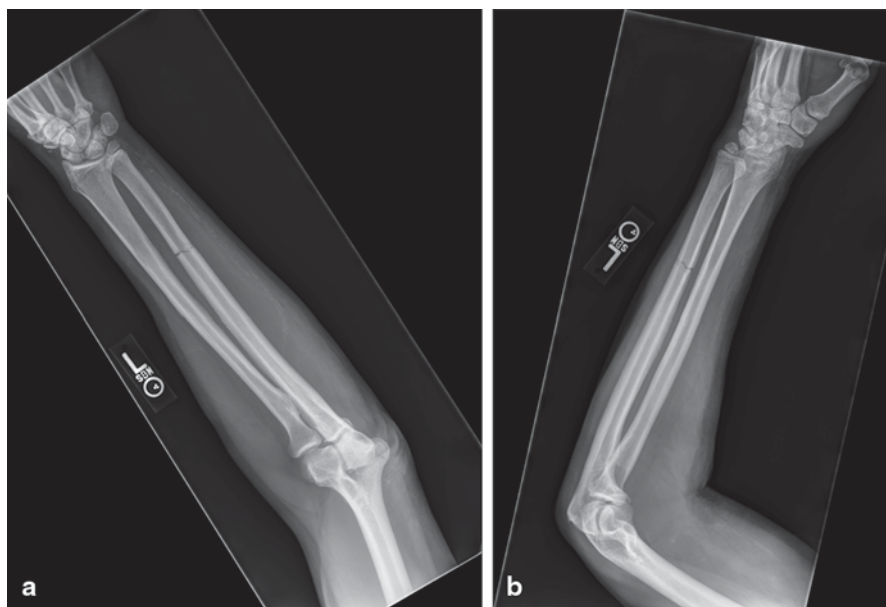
a Posteroanterior and b lateral radiographs of the forearm with ulnar stress fracture
